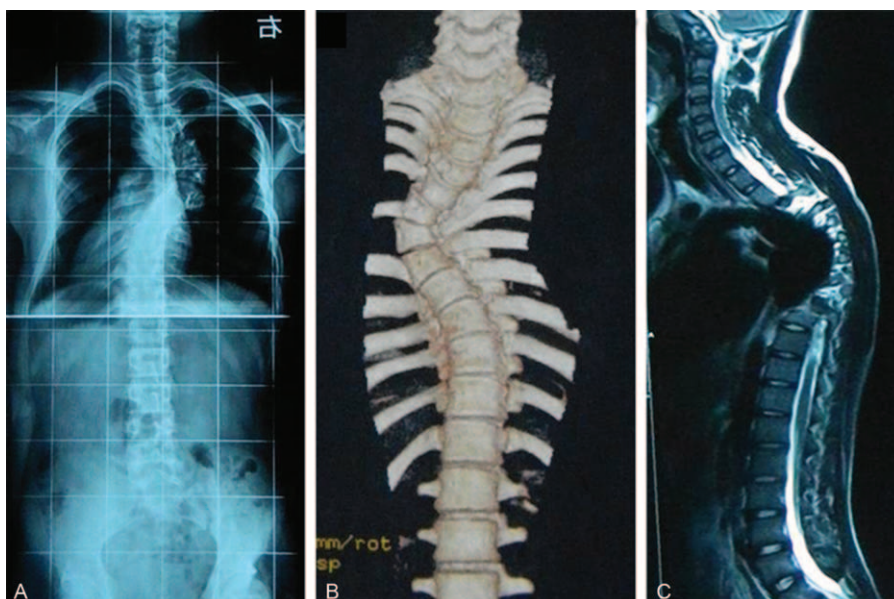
Accurately determine the deformities of dystrophic scoliosis preoperatively through X ray (A), 3D-CT (B), and MRI (C).
